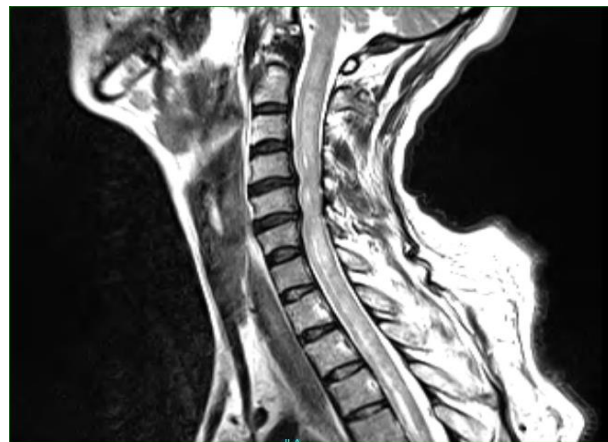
MRI image of cervical spine tuberculosis myelitis
